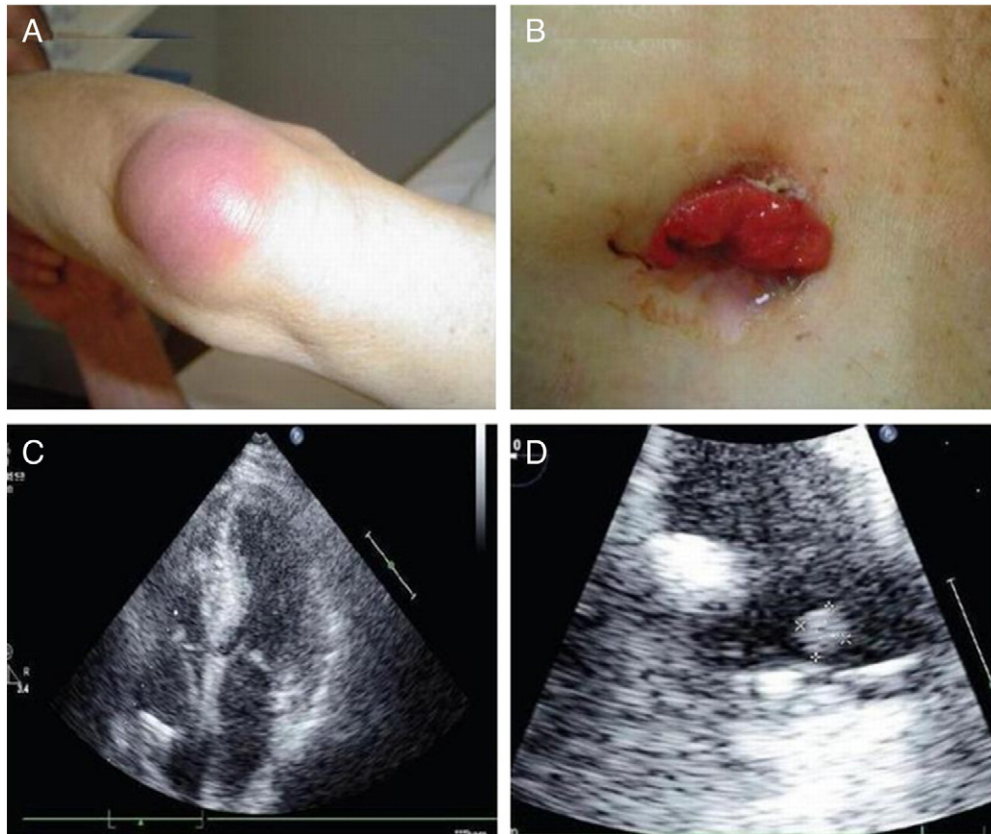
Panel A: Presence of a remarkable prepectoral area of sepsis. Panel B: Inflammatory affection of the left elbow. Panels C and D: A transesophageal echocardiography examination showed endocarditis vegetations.
